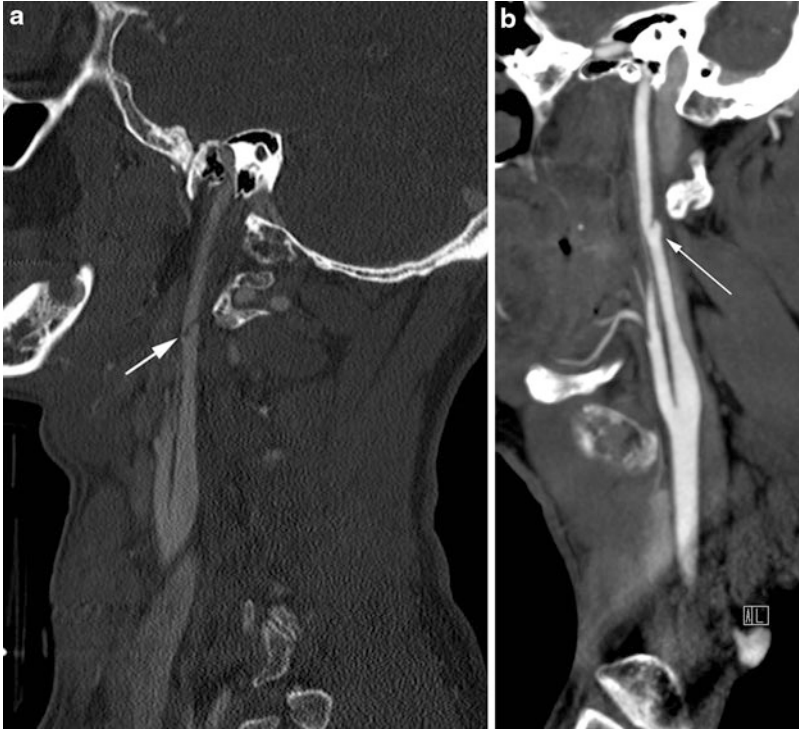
Carotid dissection and pseudoaneurysm formation. A CT angiogram (a) in a patient following a motor vehicle accident demonstrates a dissection flap in the internal carotid artery (*white arrow*). A repeat CT angiogram (b) obtained 2 months later shows formation of a pseudoaneurysm at the site of previous vascular injury (*white arrow*)
